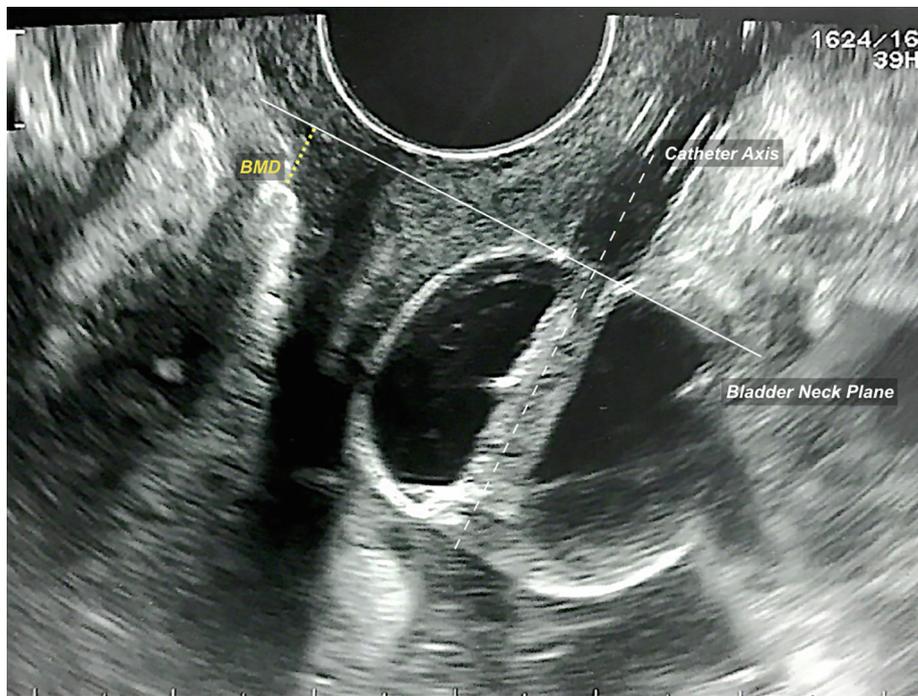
The scheme represents the method used to assess the Bladder neck - Mesh Distance (BMD, mm) by transvaginal ultrasound.
